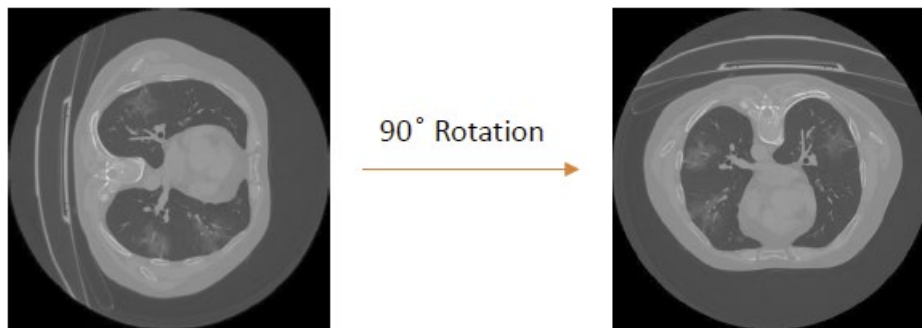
Rotation of the CT volume by 90 degrees on MosMedData [24]
